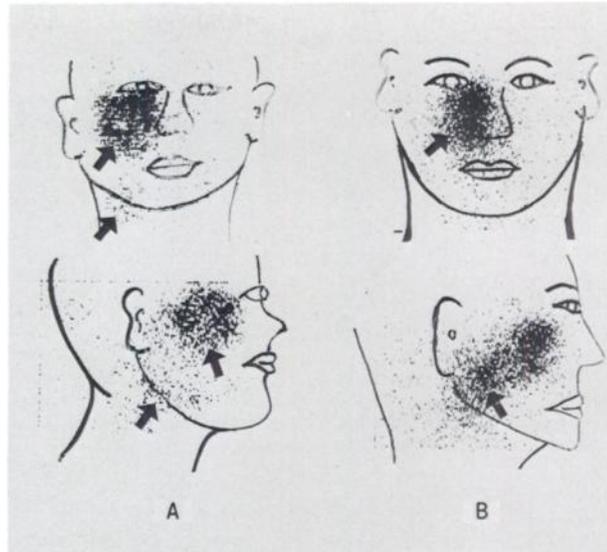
Case 9 and Case 10. Cancer of maxillary sinus. Anterior and lateral ^{67}Ga scintigrams are shown in A and B. In anterior scintigram (A) accumulation in center of tumor is less noticeable. It may be due to central necrosis. In lateral scintigram (B) infiltration to upper pharyngeal region is well demonstrated.
